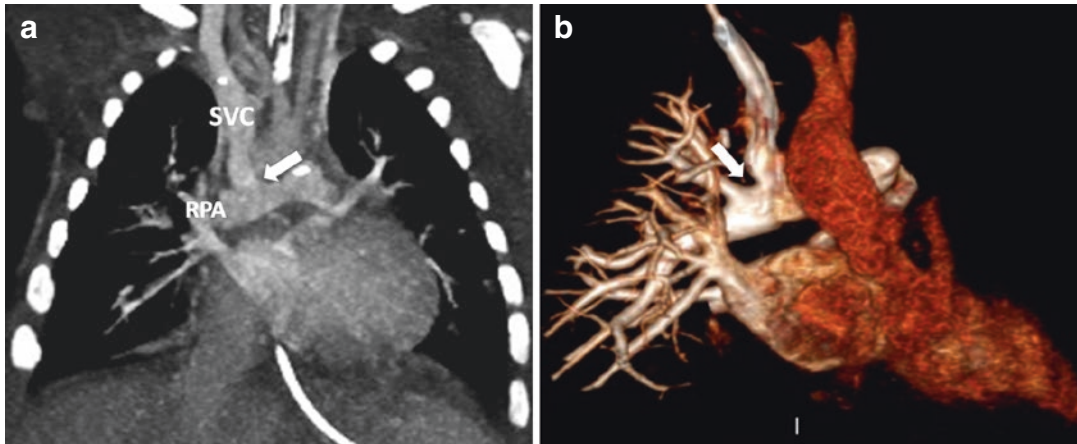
6-month-old boy with the history of tricuspid atresia status post-bidirectional Glenn. Coronal CT angiography, maximum intensity projection (a), and volume
